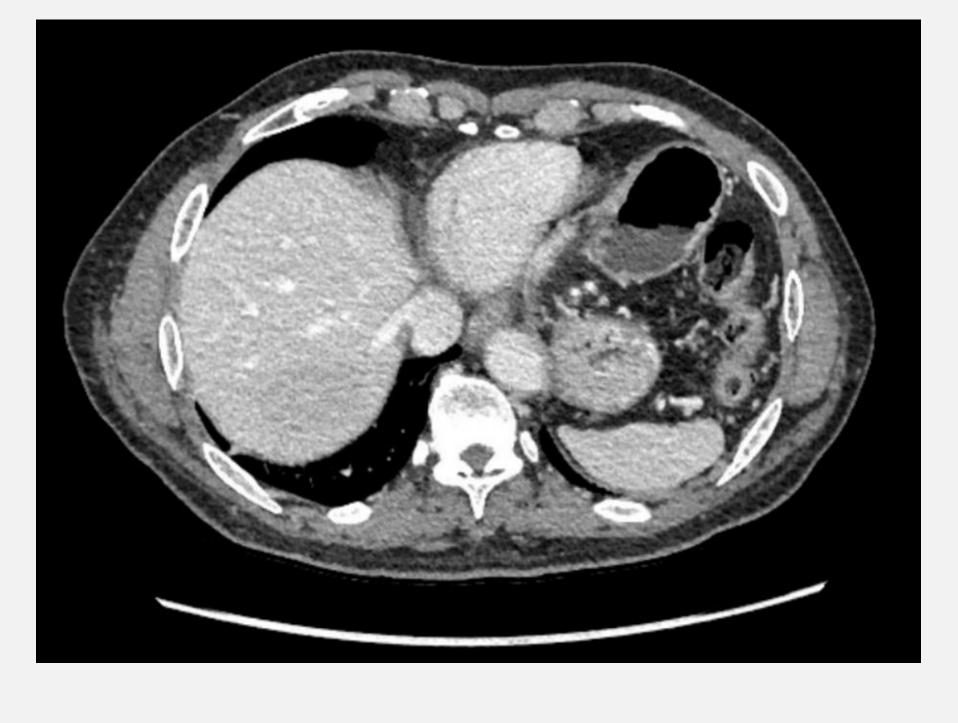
outpatient CT AP with contrast after ~7 weeks of albendazole therapy
